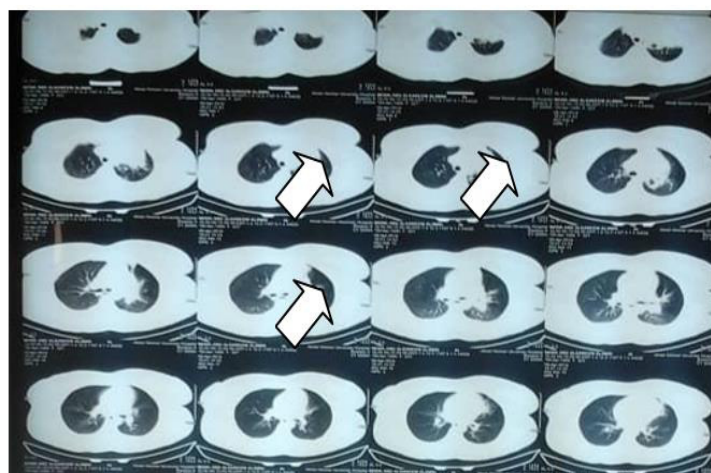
CT chest without contrast lung window
